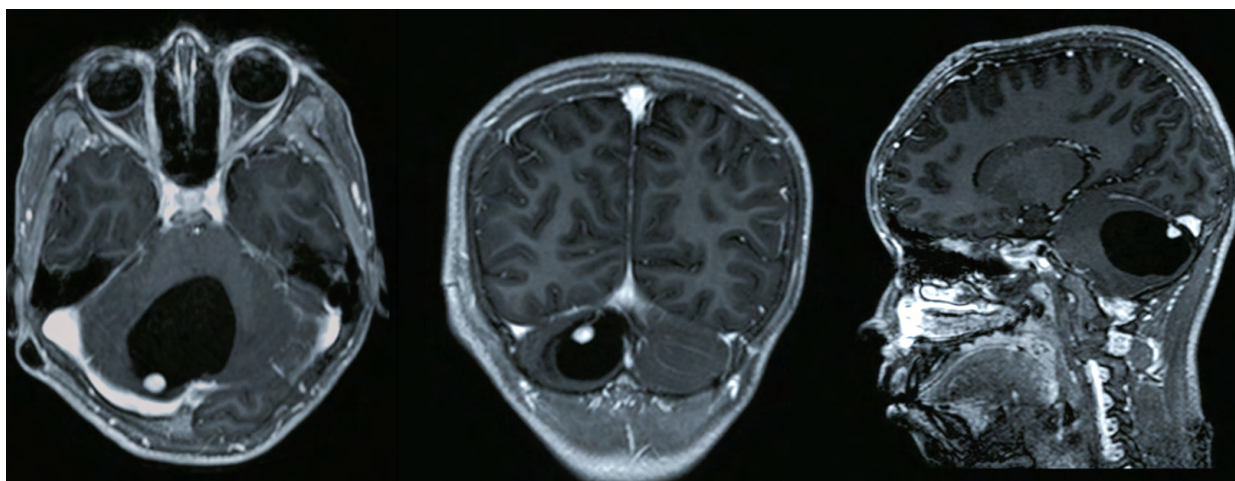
Contrast-enhanced T1-weighted magnetic resonance image in axial, coronal and sagittal views.
